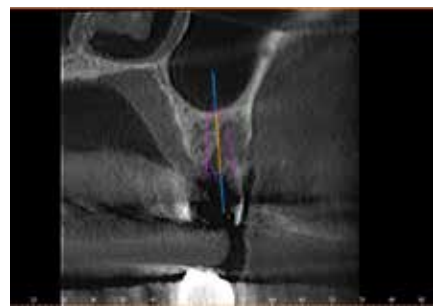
CBCT analysis allows virtual planning and placement of a future dental implant.
